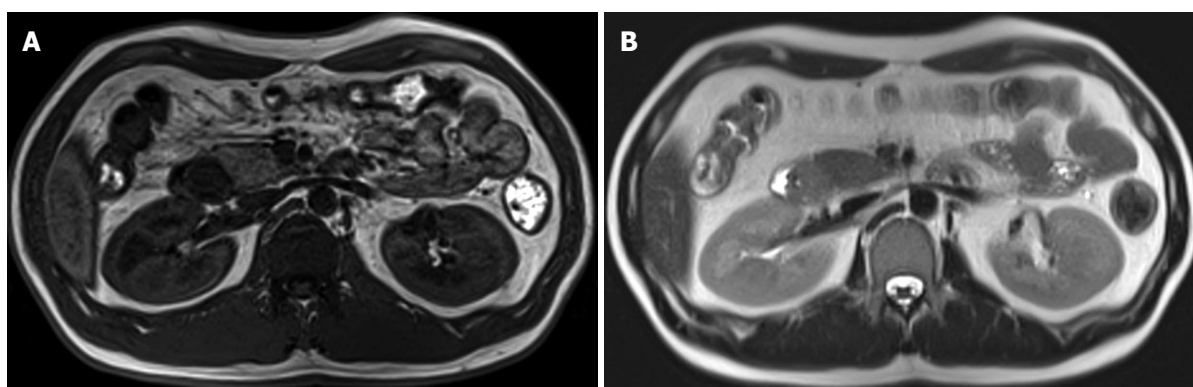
Mass showed low signal intensity on T1-weighted images (A) and high signal intensity on T2-weighted images (B).
